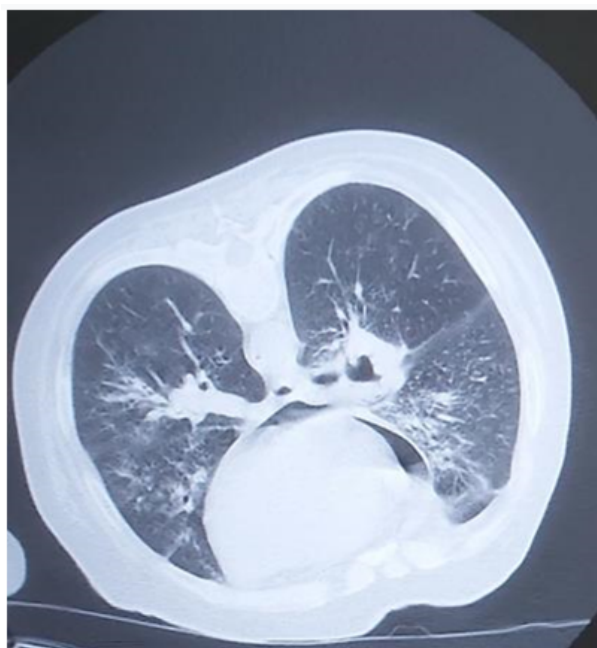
Second CT scan in prone position
